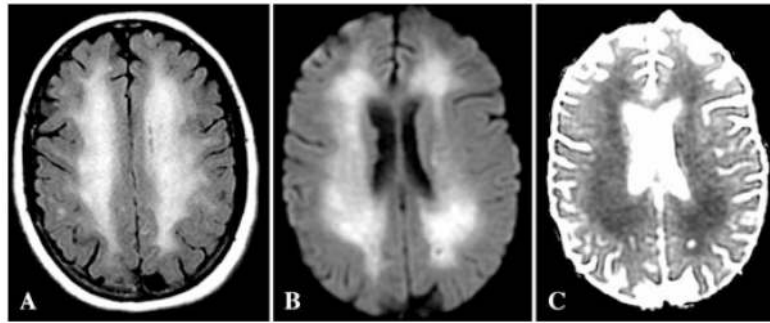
Axial MRI in delayed leukoencephalopathy after hypoxic–ischemic insult. (A) FLAIR image shows extensive, symmetric white matter hyperintensities with relative sparing of subcortical white matter. (B) Diffusion-weighted imaging shows restricted diffusion of the white matter abnormalities, confirmed on (C), apparent diffusion coefficient mapping.¹⁶⁵
